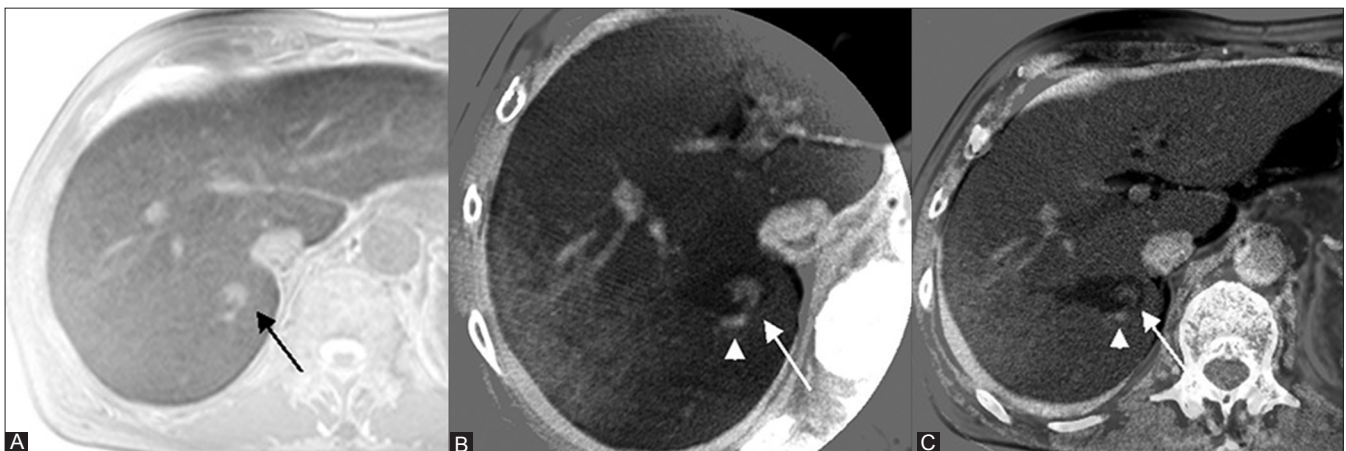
(A-C): A 66-year-old man with a 15-mm hepatocellular carcinoma. (A) An inverted hepatobiliary-phase MR image obtained before RFA showing the target tumor (arrow) at hepatic segment VII. (B) A transverse fusion image of intra-procedural contrast-enhanced C-arm CT and pretreatment hepatobiliary-phase MR image revealing insufficient ablation margins (arrow) due to the heat-sink effect of the adjacent portal vein (arrowhead). (C) A fusion image of a portal-phase multi-detector CT image and a pretreatment hepatobiliary-phase MR image showing an insufficient ablation margin (arrow) and an adjacent portal vein (arrowhead) that are similar to those seen in the C-arm CT fusion image.
